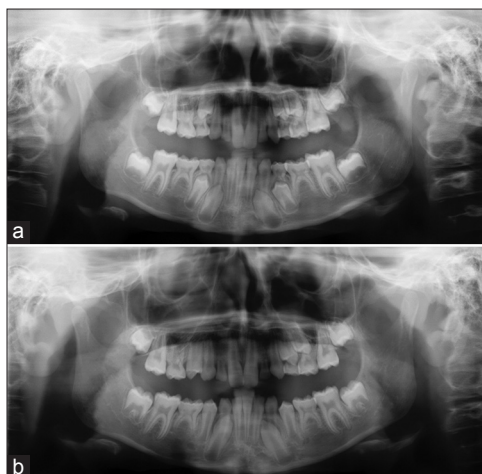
(a and b) Panoramic radiograph at the initial examination, above teeth were missing: The consecutive panoramic radiograph was taken 18 months later (below). Retained deciduous maxillary lateral incisors and mandibular second molars showed some degree of root resorption
